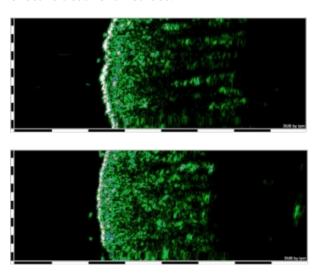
Ultrasound picture of the upper back MA lesion (upper picture) and control (lower picture), decreasing
